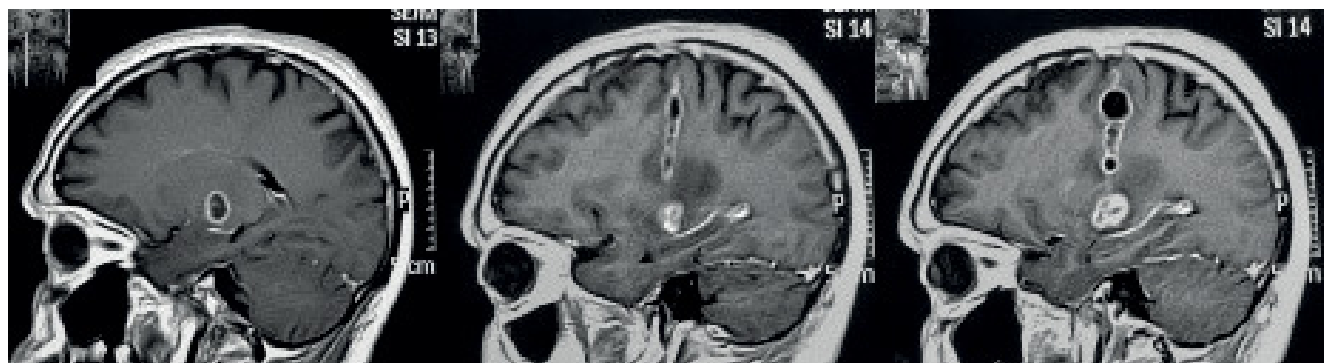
Tumor seeding developing within the tract of a stereotactically-guided biopsy in a patient with metastatic adenocarcinoma from lung cancer further submitted to gamma knife surgery. Basal MRI shows a thalamic metastasis (*left*). Increasing tumor seeding along the surgical tract was noted four (*center*) and six months (*right*) after the procedure.
